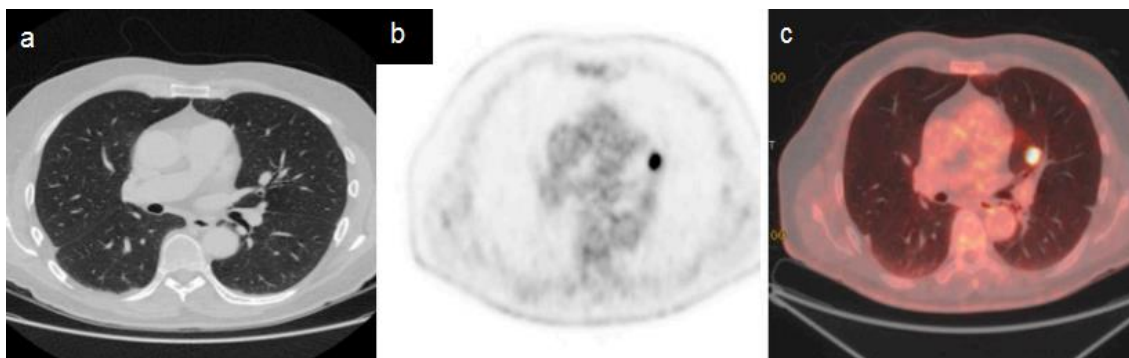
Paciente com histórico de neoplasia colorretal, com nódulo pulmonar que foi posteriormente confirmado, através de análise histopatológica, tratar-se de metástase. a. TC evidenciando nódulo no pulmão esquerdo. b, c. Imagens axiais de PET e PET/CT, respectivamente, mostrando alta avidéz da lesão ao FDG, com SUVmax de 10.9. Figura adaptada de Sim e cols., 2013.
